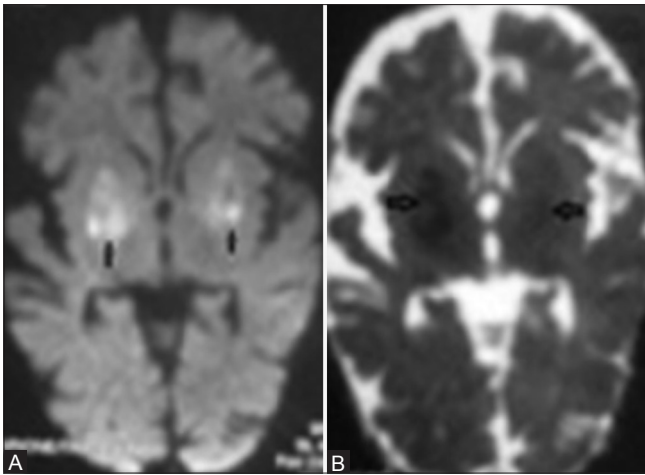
(A and B): Axial diffusion-weighted MRI at b value of 1000 s/mm² (A) at the level of basal ganglia shows hyperintense signal intensity in bilateral lentiform nuclei (arrow). ADC map (B) at the same level shows reduced ADC value in bilateral lentiform nuclei seen as hypointense signal (arrow)
